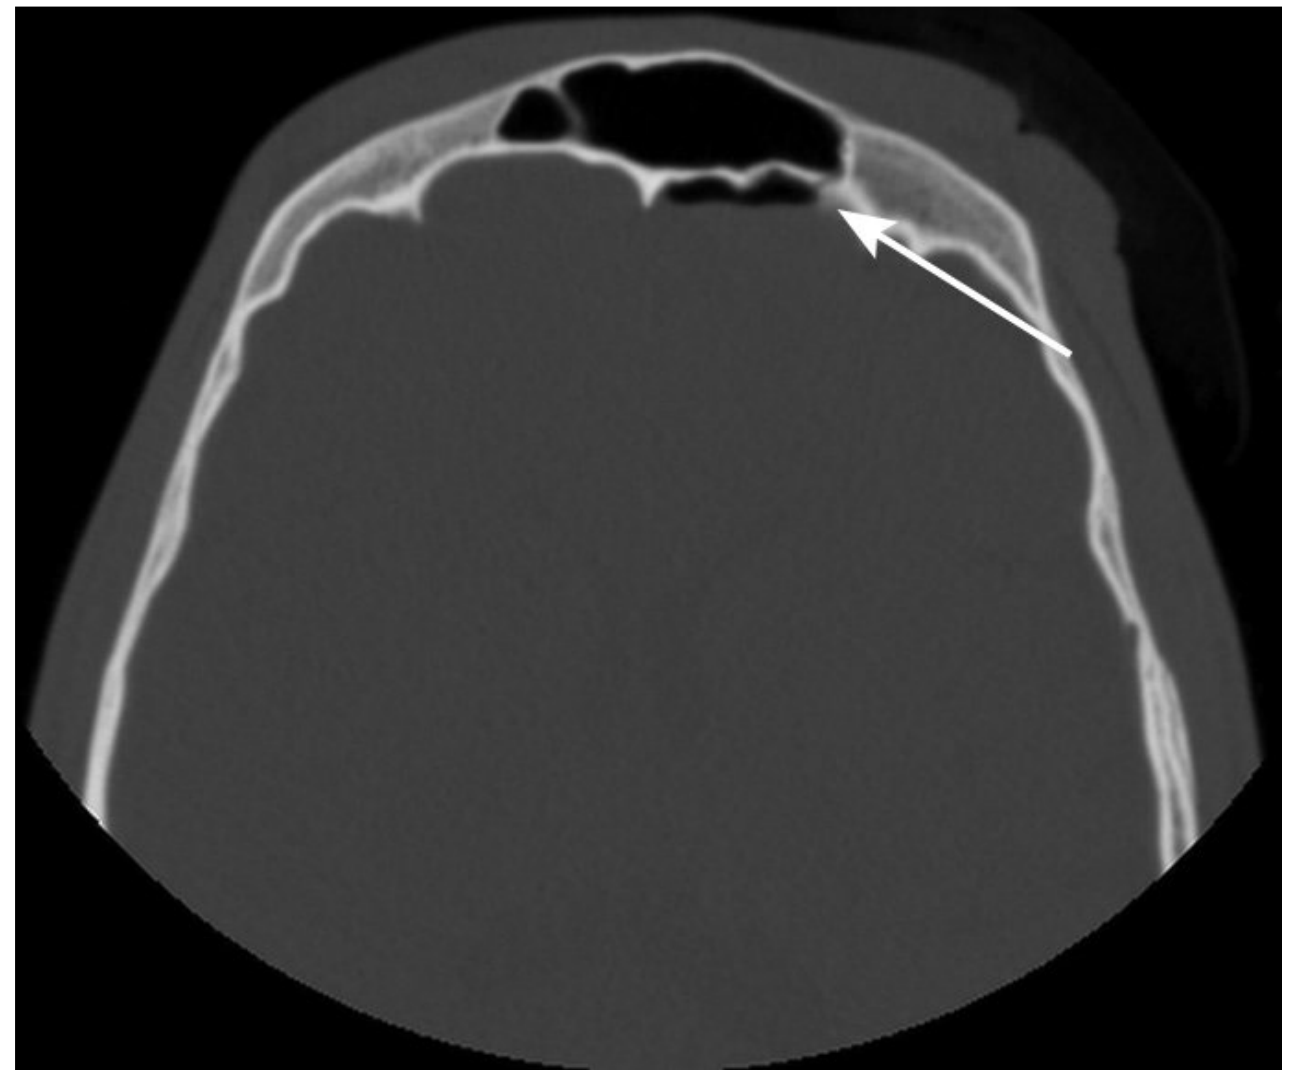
CT demonstrating an isolated fracture (arrow) of the posterior table of the frontal sinus. Note the presence of pneumocephalus.
